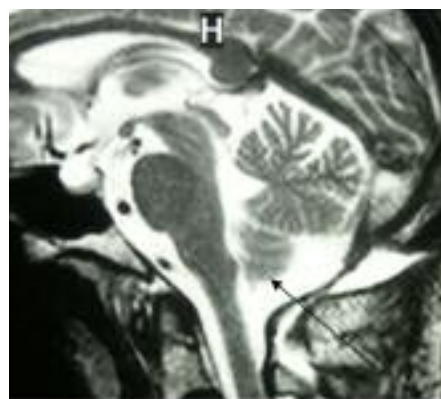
Postoperative sagittal T2-weighted MRI showing the left cerebellar mega-tonsil (black arrow) with no more mass effect.
